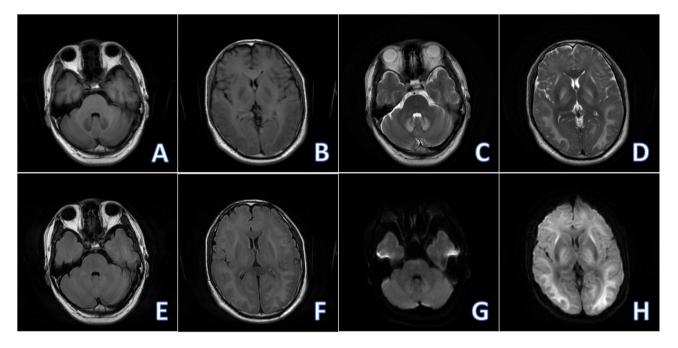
Non-contrast brain MRI (2023-04). (A-H) There were reductions in the extent of the abnormal signal in the brain and in the DWI intensity of the lesion compared with the earlier scans (at 11 days post-admission). MRI, magnetic resonance imaging; DWI, diffusion-weighted imaging.
